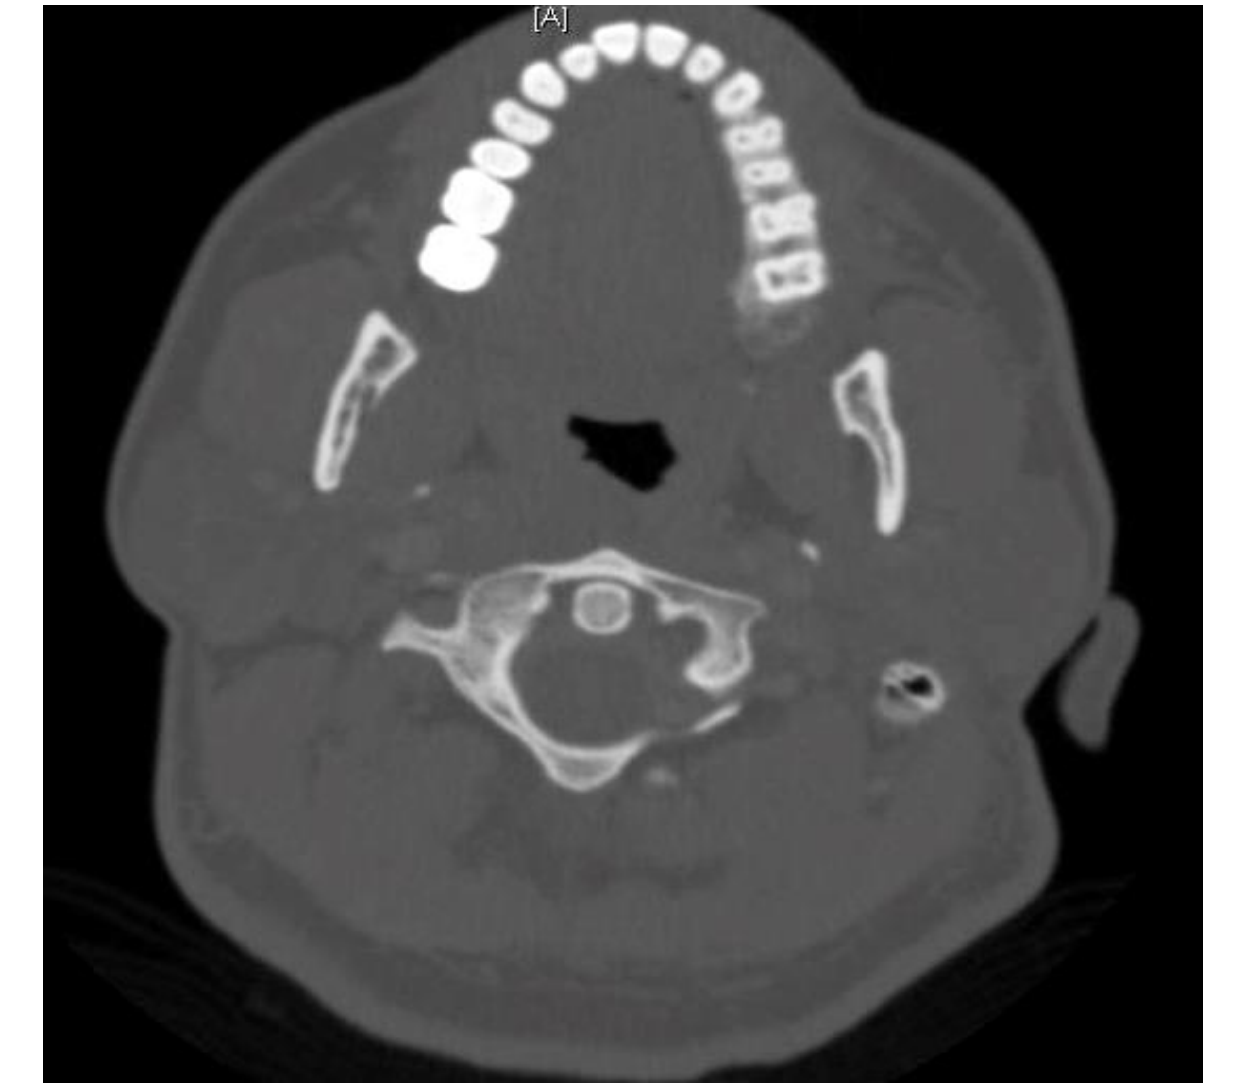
CT neck with contrast with axial view, bone window at the level of C1 and C2. No osseous destruction noted.
